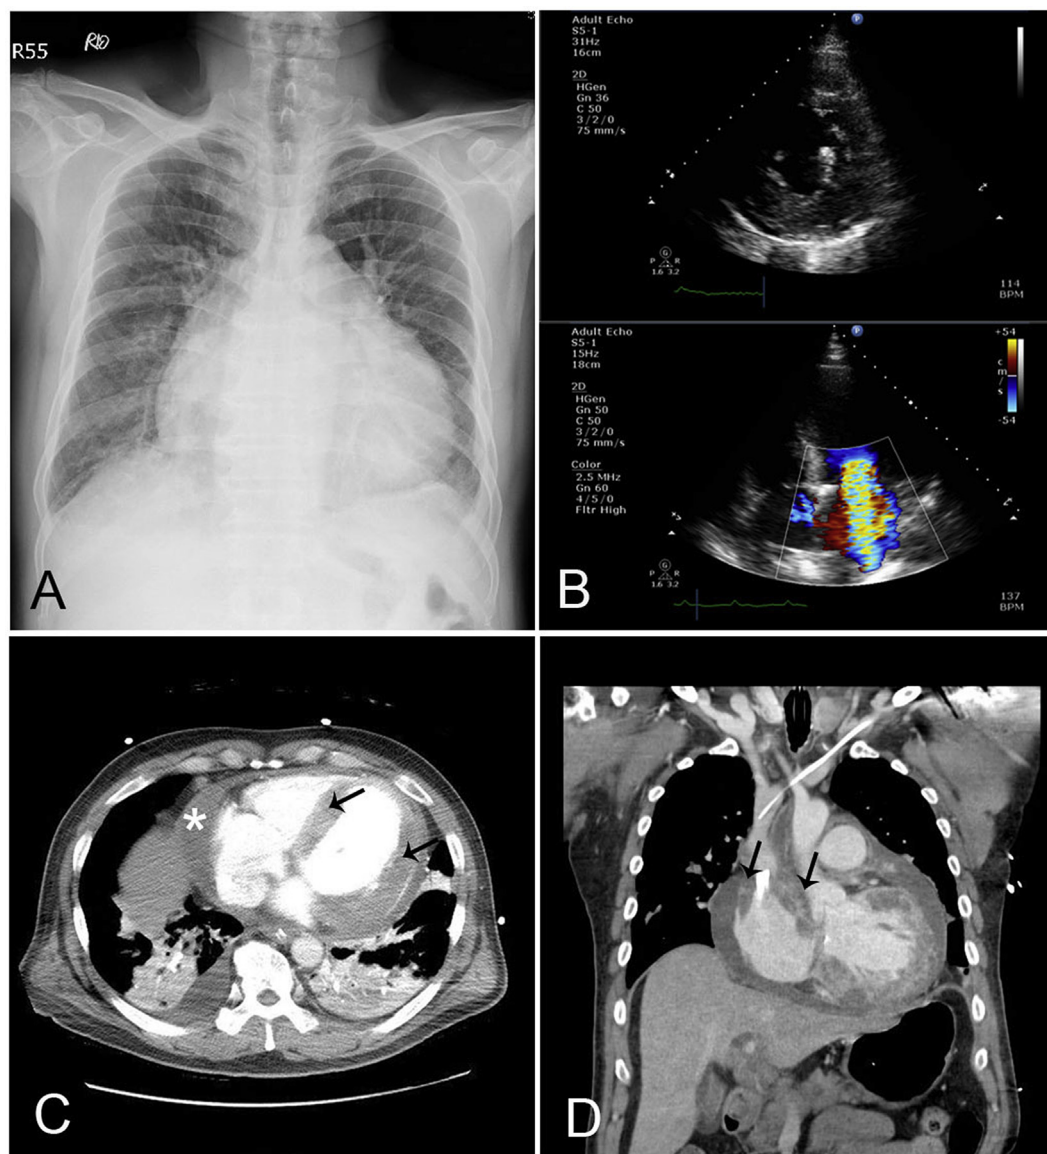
Chest X-ray, echocardiography, and CT. Chest X-ray revealed cardiomegaly and pulmonary congestion (A). Echocardiography showed hypertrophy at the posterior lateral wall of the left ventricle, impaired left ventricle contractility, and severe mitral regurgitation (B). Computed tomography (CT) revealed heterogenous enhancement in the left ventricular myocardium (arrow) and a moderate amount of pericardial effusion (asterisk) (C). The reconstructed coronal view of the chest CT revealed a right atrial mass (arrow) (D).
